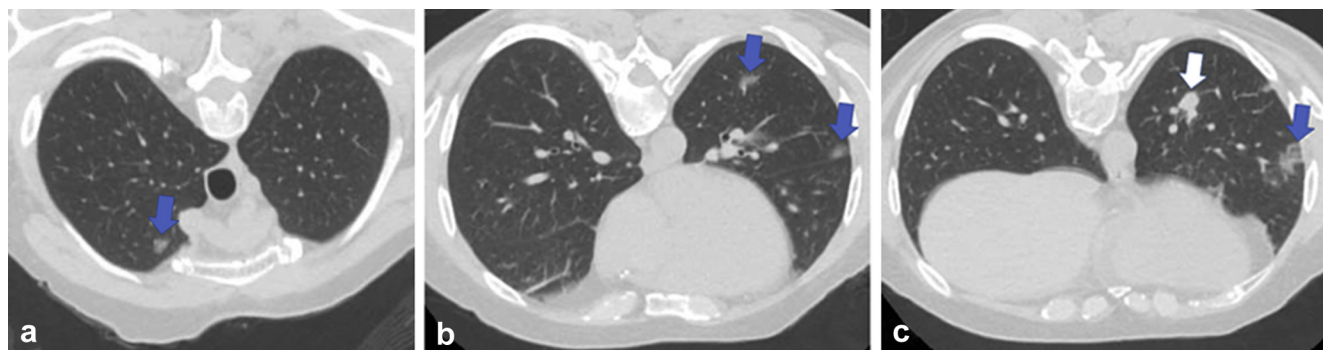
CT images obtained in the prone position before CT-guided transthoracic lung biopsy, from cranial to caudal (a–c). There are multiple new ground-glass opacities in the lung periphery, some with a rounded morphology (blue arrows). The suspicious left lower lobe nodule persists (white arrow).
